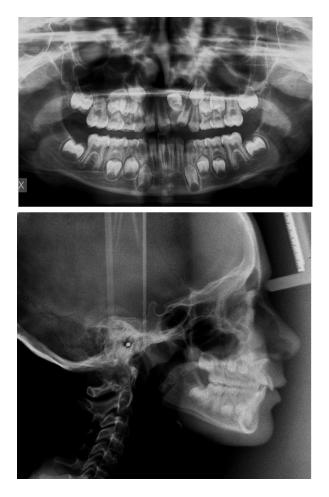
A, panoramic radiograph; B, lateral cephalogram.
